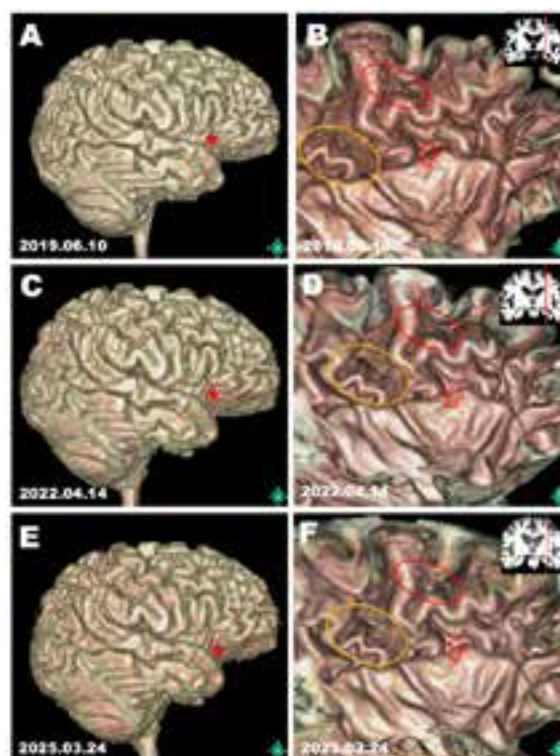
MRI scans were acquired on June 10, 2019; April 14, 2022; and March 24, 2025, before and during follow-up after cytokine-based therapy. Panels A, C, and E show three-dimensional reconstructions of the cerebral cortex, presented as lateral views of the right hemisphere, generated in silico from T1-weighted MRI data with 1-mm sagittal slices using Expert INTAGER software. Panels B, D, and F show cut-surface images of the left prefrontal region corresponding to the red lines shown in the upper-right insets. Red arrows and red and yellow circles indicate subcortical vascular lesions, and red asterisks indicate the Sylvian fissures.
